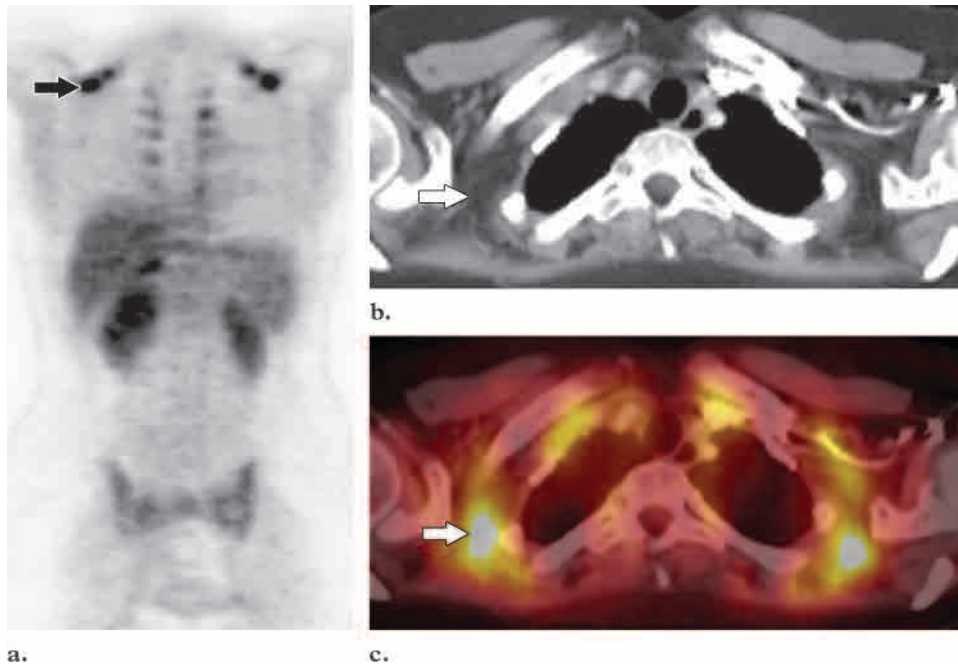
Physiologic brown fat uptake. (a) Coronal PET scan shows bilateral foci of intense FDG uptake in the posterior superior thorax (arrow). (b) Axial CT scan shows no correlative abnormality. Arrow indicates an area of fat attenuation. (c) Axial fused PET-CT scan helps localize the foci precisely to areas of fat attenuation seen at CT (arrow).
